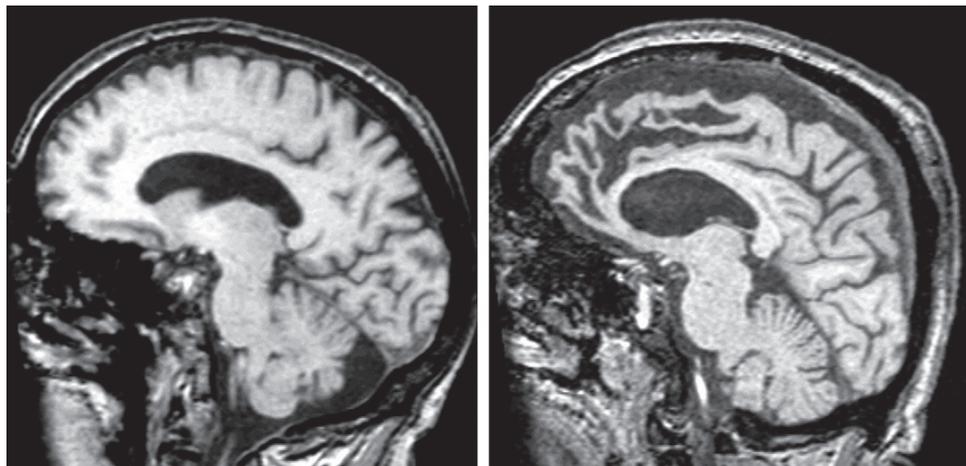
Parasagittal image from MRI of a patient with frontotemporal dementia (left). Atrophy of the frontal lobes is dramatic compared with the brain of a normal individual (right). (Courtesy of Maria Shiung and Clifford Jack.)
